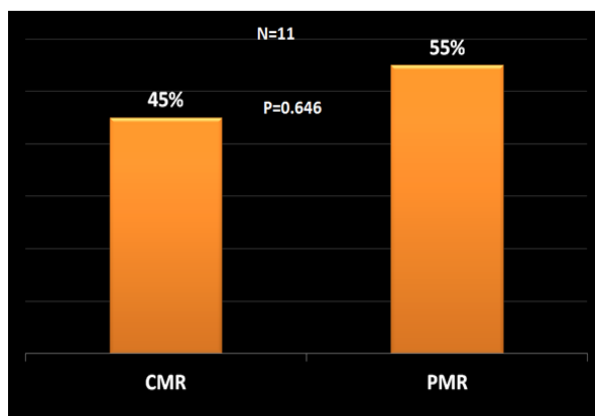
Metabolic response on Follow-up <sup>18</sup>F-FDG PET/CT in Esophageal Cancer Patients who Underwent Neoadjuvant Chemoradiation (nCR).
